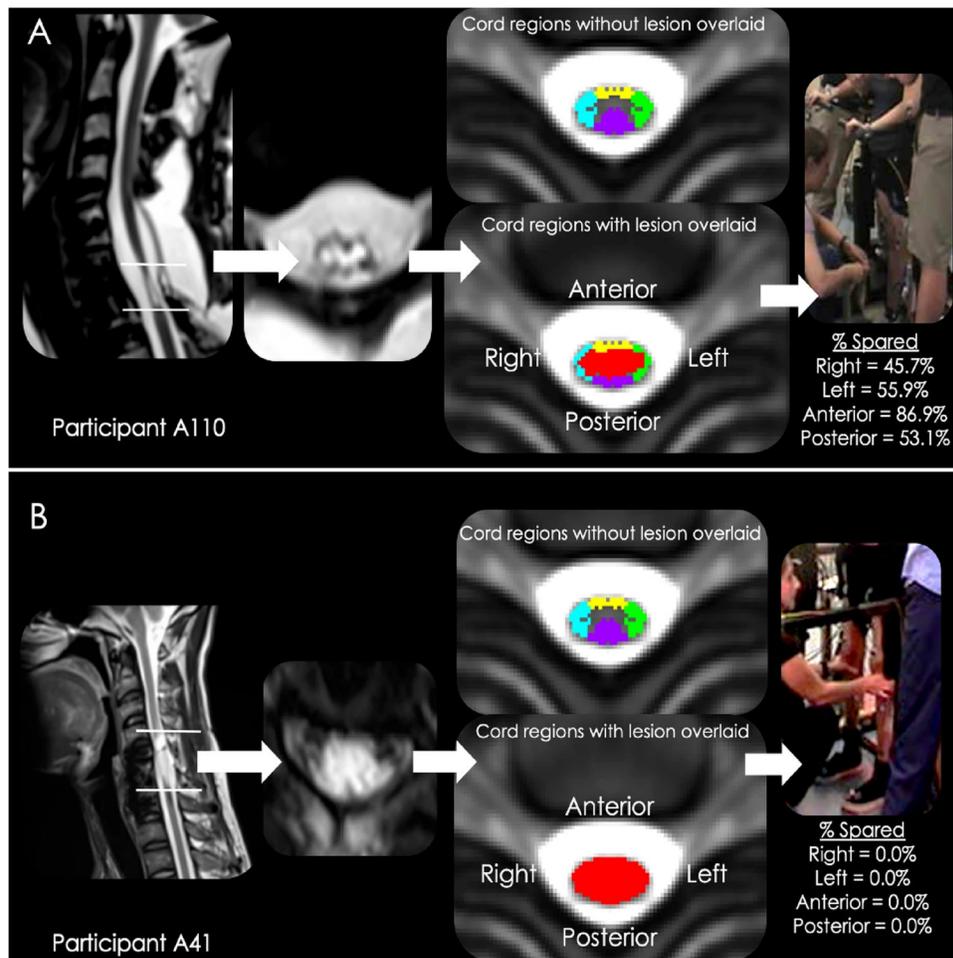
Imaging results from two representative research participants. A depicts an individual (A110) who demonstrated more spared cord in all regions and also better scES-promoted standing ability. B represents an individual (A41) who did not show spared cord tissue in the four regions of interest or any ability to achieve independent extension of either lower limb. From left to right: a mid-sagittal T2-weighted image with lesion hyperintensity visible, an axial T2-weighted image with lesion hyperintensity visible, the axial template showing each participant's aggregated damage with the four regions depicted, and the percentages of spared tissue in these regions corresponding to standing ability with scES on.
